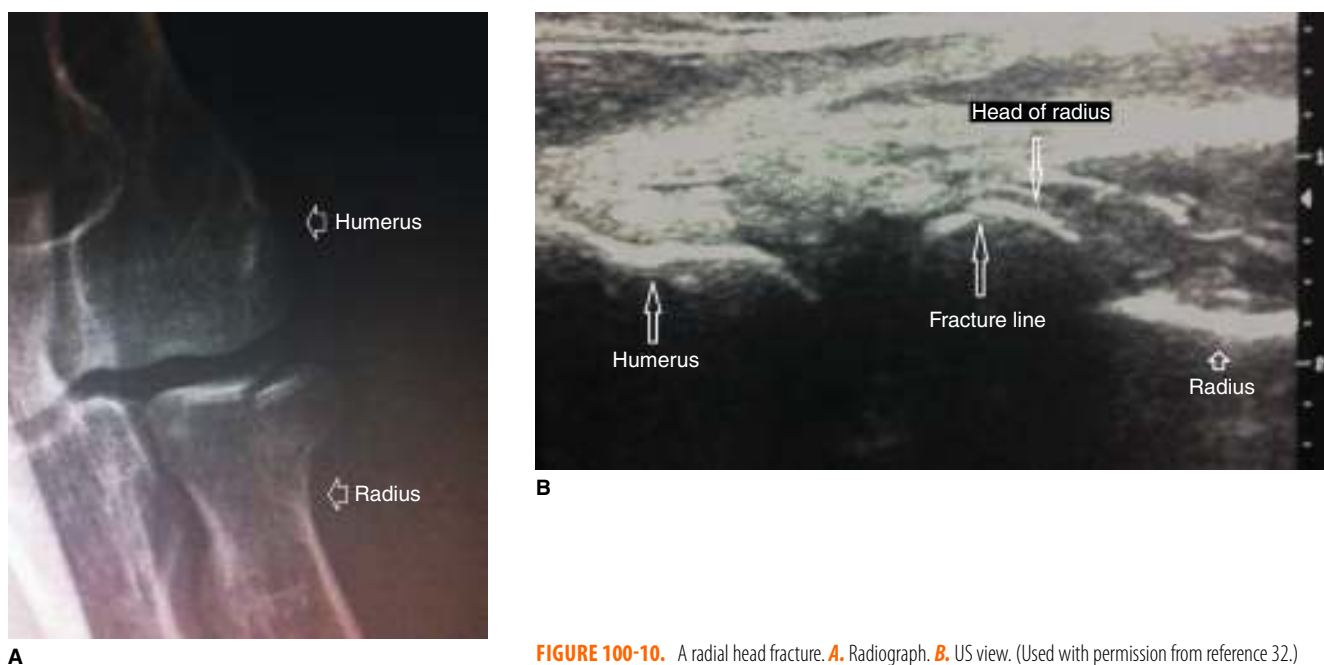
A radial head fracture. A. Radiograph. B. US view. (Used with permission from reference 32.)
